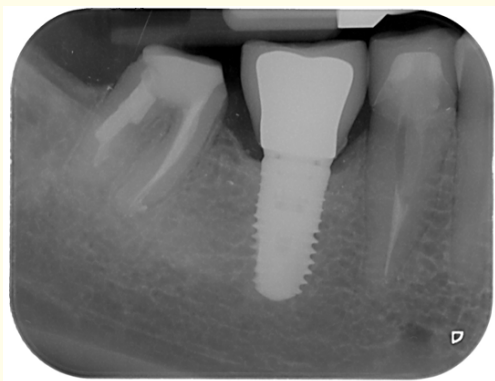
Periapical x ray at the delivery of the final prostheses.
